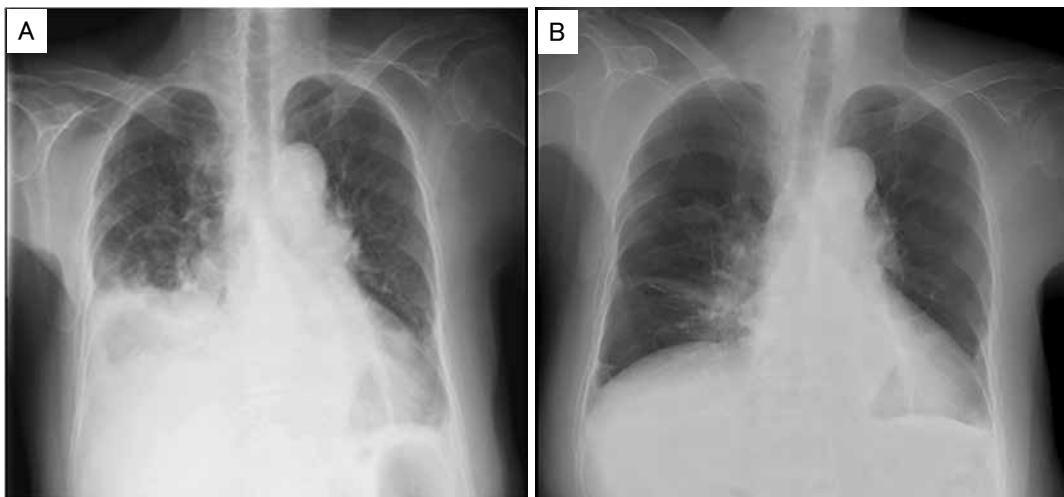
Chest radiography on admission, and after corticosteroid administration. A right pleural effusion was observed (A), which was barely evident after 14 days (B).
